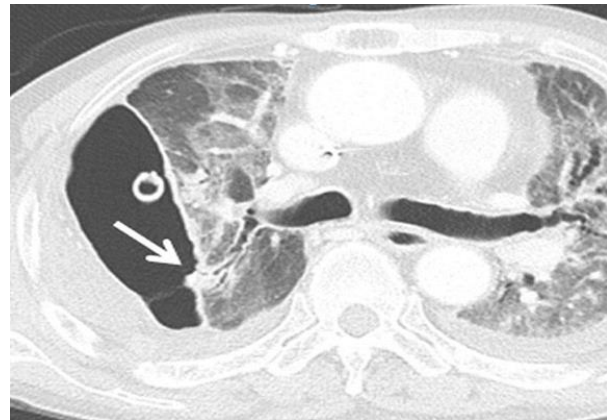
CT imaging after thoracic surgery
